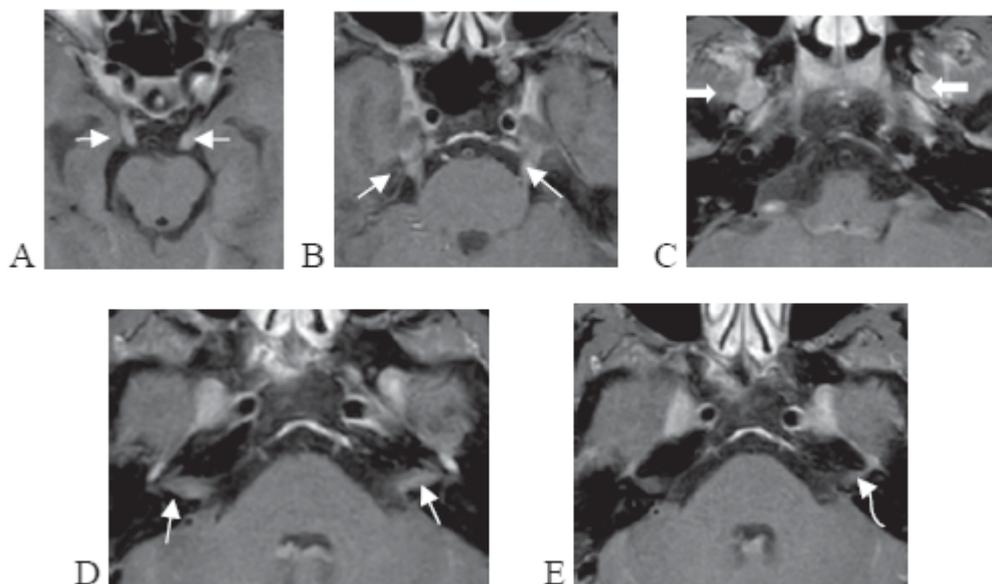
Case 3: acute myeloid leukemia (AML) with CN involvement: A 45-year-old male presented with 2 months of bilateral amblyopia and suspected bilateral CN III palsy. He had underlying of AML. MRI of the brain axial post gadolinium T1WI demonstrated thick enhancement along bilateral CN III, CN V, CN VIII, facial nerves (A, B and D, respectively, white arrows), anterior labyrinthine segment of left facial nerve (E, curve arrow) and bilateral foramen ovale (C, thick white arrows).
